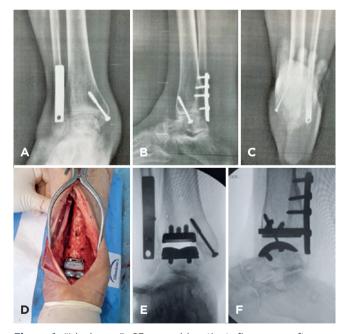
"Ideal case". 63-year-old patient, five years after osteosynthesis of the right ankle, ankle arthrosis with dorsiflexion block, without comorbidities. A. AP ankle radiograph showing a reduction in ankle joint space and good alignment in the coronal plane; B: Lateral ankle radiograph showing ankle arthrosis, the presence of an anterior osteophyte with dorsiflexion block. C. Saltzman radiograph showing good hindfoot alignment. D: Intraoperative image after implantation of the ankle prosthesis (Infinity®). D. Fluoroscope image in AP view of the ankle with good implant alignment and restoration of the joint line. E and F. Fluoroscope image in lateral view of the ankle with good implant alignment and positioning.
